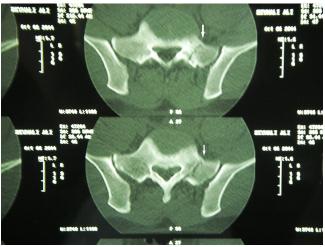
Post reduction Computerized Tomography (CT) scan demonstrates the left posterior pelvic ring lesion through the fracture of the sacrum.
